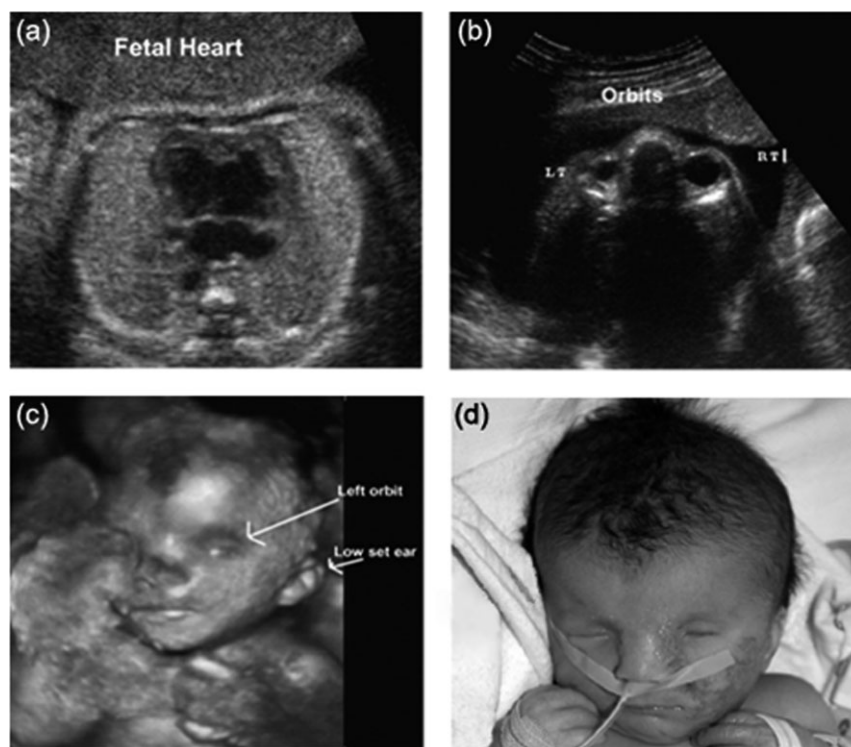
Ultrasound images at 28 3/7 weeks' gestation showing the (a) fetal heart, (b) ocular orbits and (c) three-dimensional image of the fetal face. Linear skin defects on the face typically seen in MLS patients are notable after birth (d)
